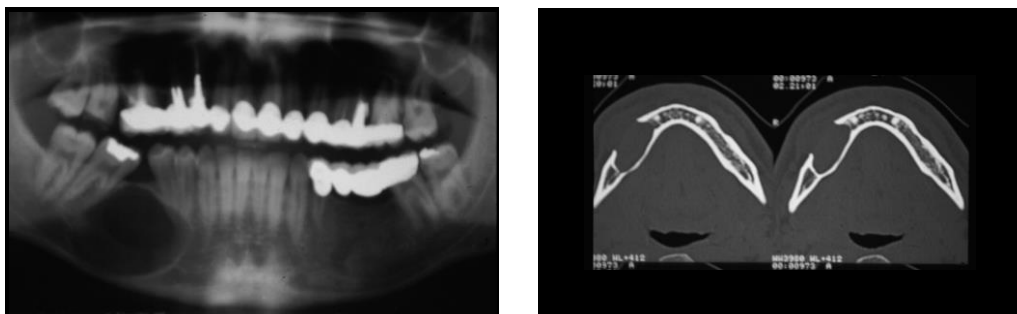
OPG and CBCT demonstrate the presence and extent of the cyst.
